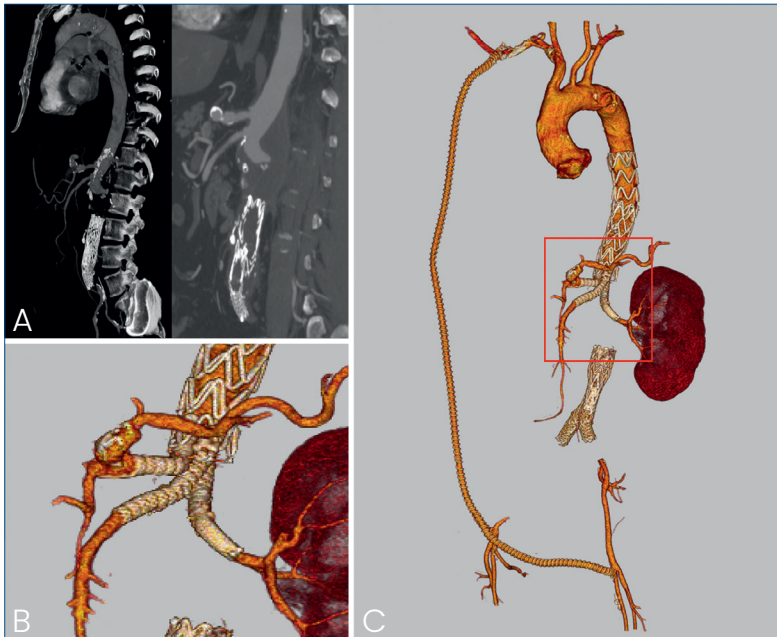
● A) Preoperative CT of thoraco-abdominal aortic aneurysm in a patient with aorto-iliac occlusion after regular EVAR; B) focus on the distal part of the endograft with bridging stents; C) CT scan reconstruction of a B-EVAR deployed from axillary artery.
